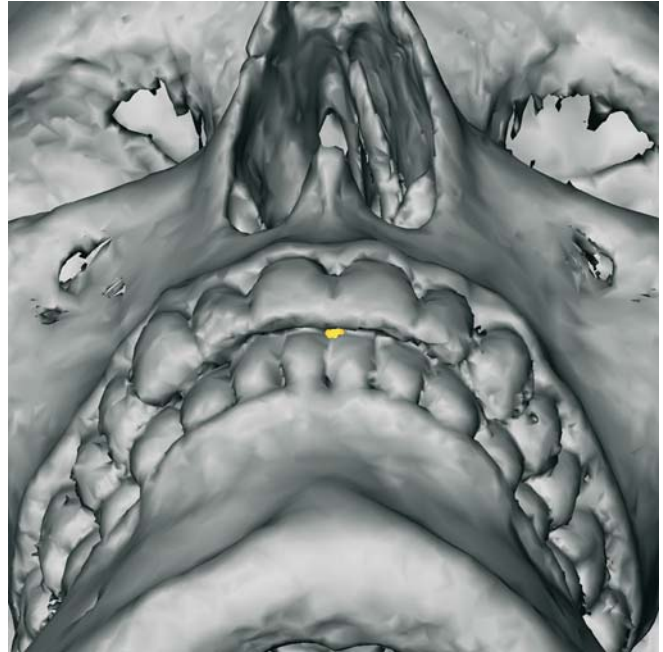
Lower Incisor_l, Submental view (3-D CT, patient K.C.)
